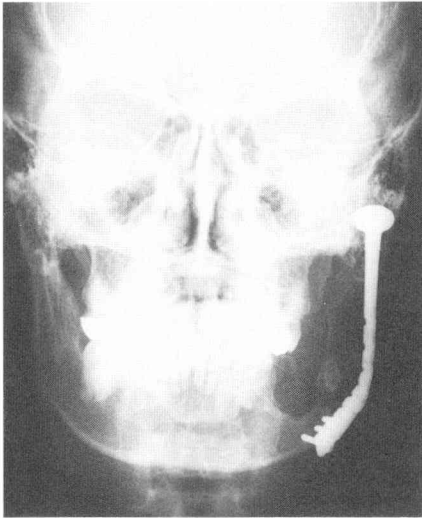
P-A X-ray view and frontal facial view at 2 years and 11 months after operation. Functional and aesthetic reconstruction was achieved.
